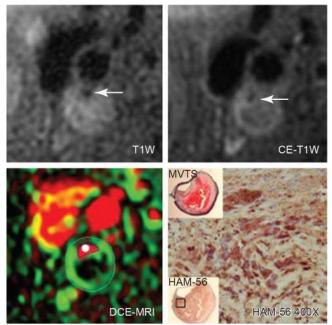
Dynamic contrast-enhanced MRI of an inflamed fibrous cap of plaque (in T1W and CE-T1W) shows high transfer constant (green) in the adventitial vasa vasorum (near the outer vessel wall boundary) and along the lumen boundary (inner boundary demarcating red lumen region). (Modified from Chu B, Ferguson MS, Chen H, et al: Cardiac magnetic resonance features of the disruption-prone and the disrupted carotid plaque. JACC Cardiovasc Imaging 2:883, 2009.)
